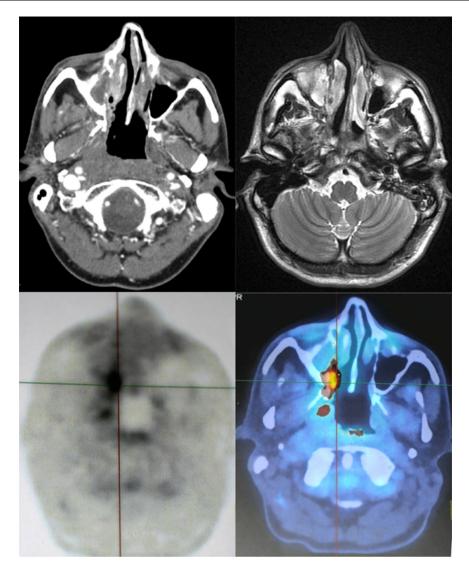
PET-CT, axial scan. PET demonstrates significant uptake (SUVmax 12) in the right pterygopalatine fossa (lower images), while recurrence is not clearly visualized on contrast-enhanced CT (left upper image) and MRI axial sections (right upper image).
